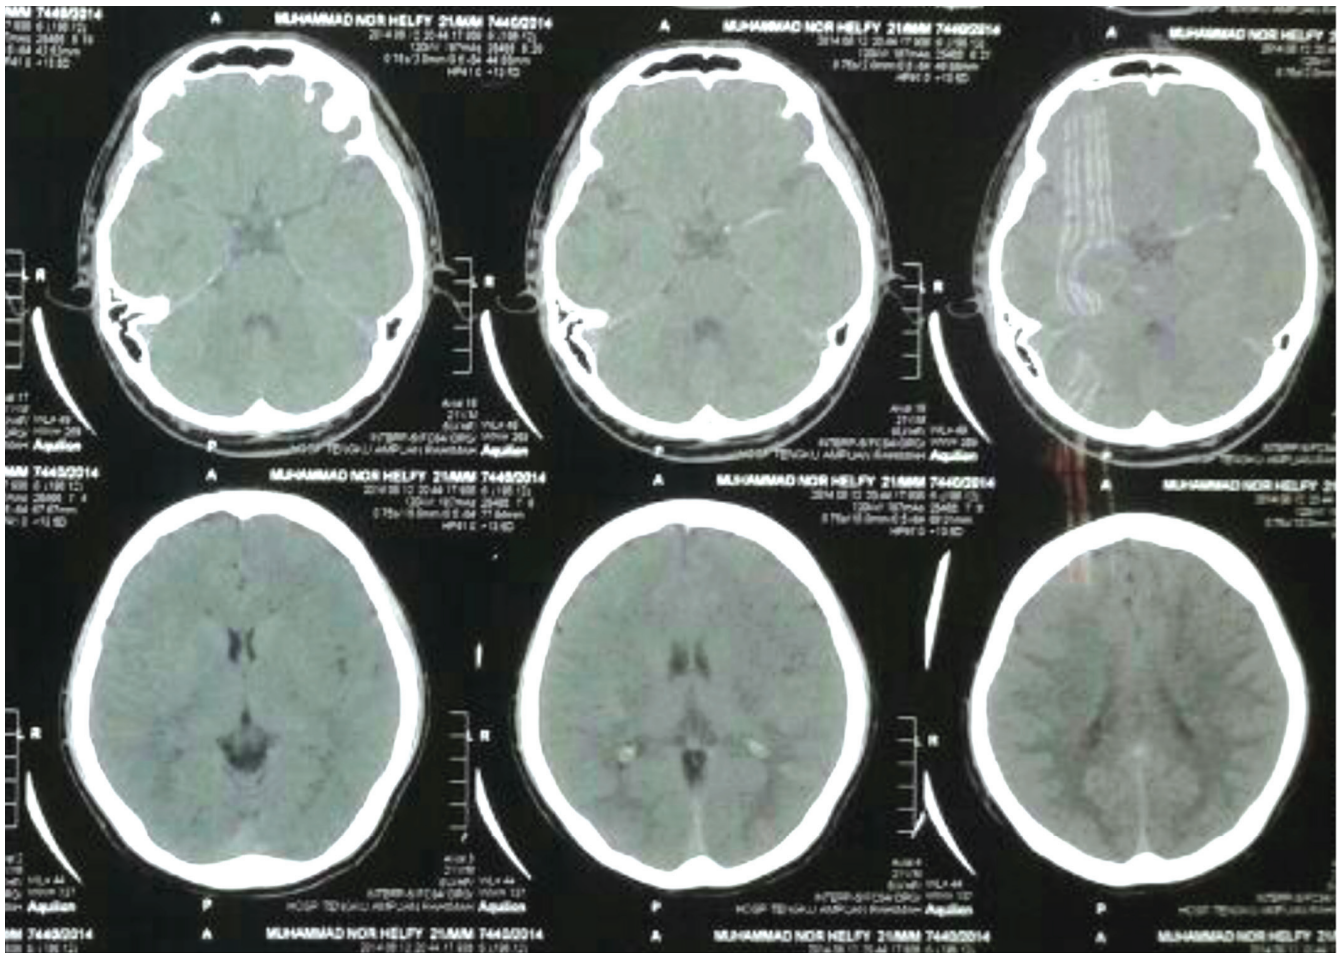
Initial CT Brain showing no ICB
